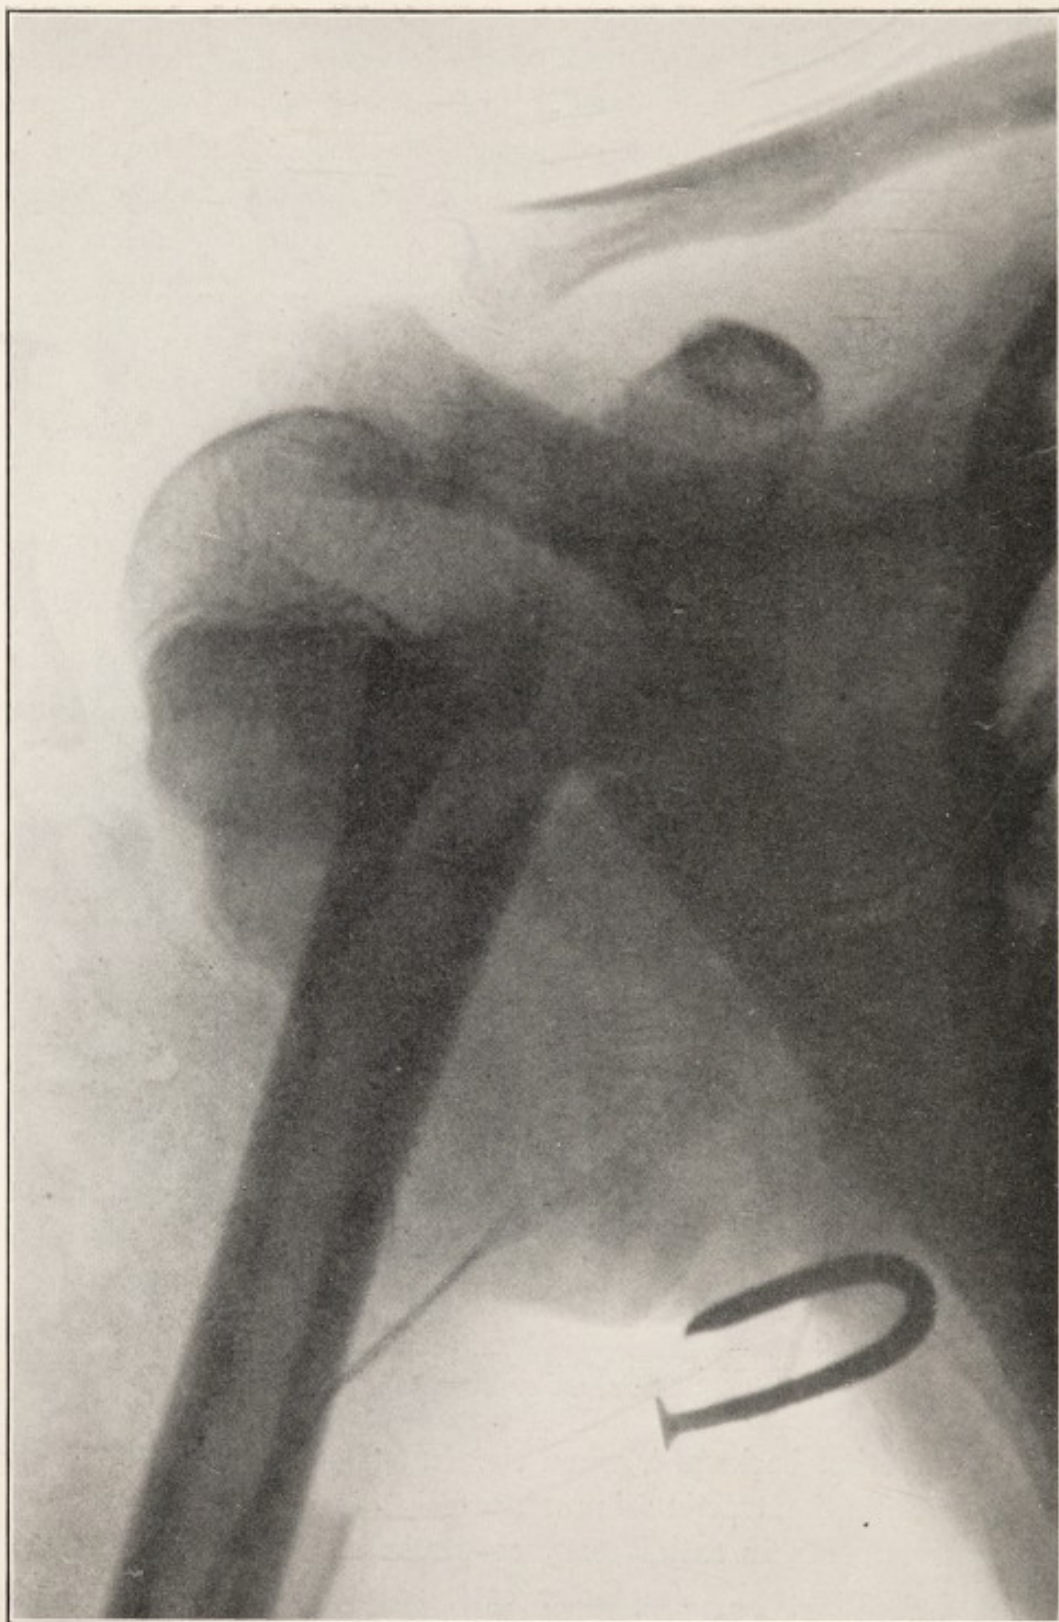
X-RAY SHOWING FRACTURE OF SURGICAL NECK OF HUMERUS.
